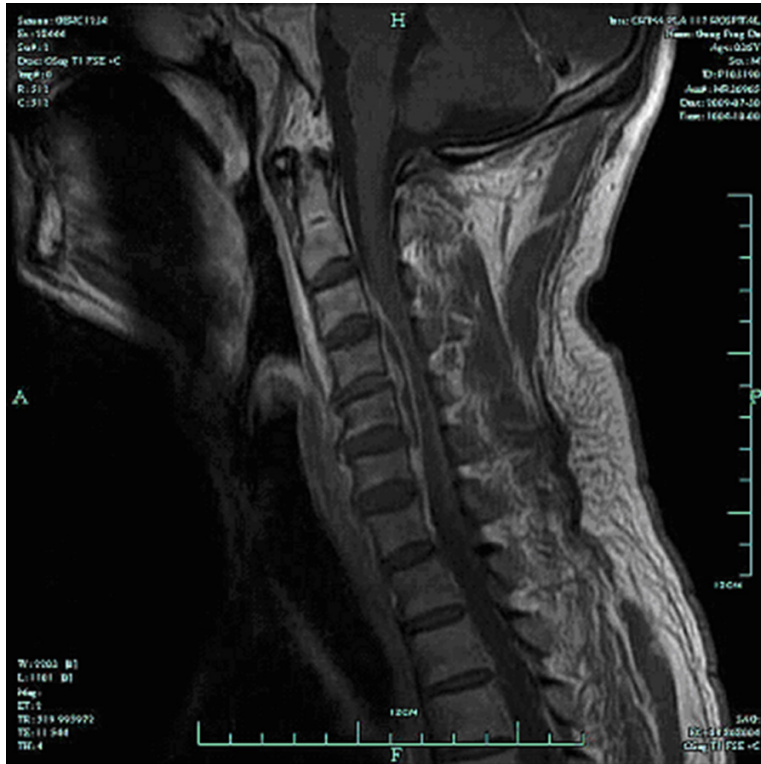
The sagittal enhanced MRI two days after initial MRI. The abscess became larger and extended from C3 to C7.
